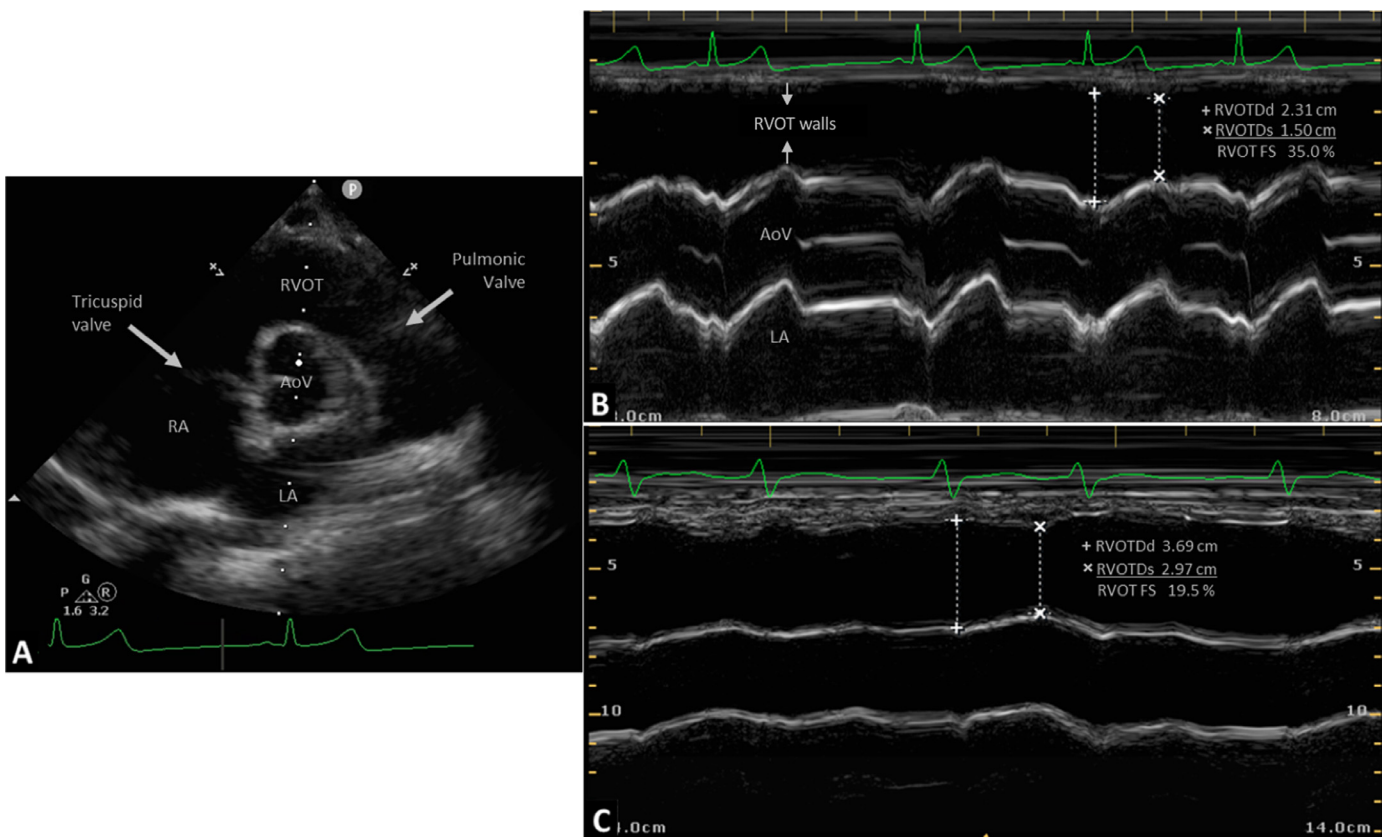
Right ventricular outflow tract fractional shortening by transthoracic echocardiography. (A) Two-dimensional image of parasternal short-axis view, aortic valve level describing the image acquisition before M-mode imaging of right ventricular outflow tract fractional shortening; the M-mode line (white dotted line) is placed through the right ventricular outflow tract, aortic valve, and left atrium; then, M-mode imaging can be recorded. The right atrium, tricuspid valve (left arrow), and pulmonary valve (right arrow) also are seen. (B) M-mode image of normal right ventricular outflow tract fractional shortening (35.0%) suggesting normal right ventricular function. The right ventricular outflow tract walls (arrows), aortic valve, and left atrium are depicted across several cardiac cycles. (C) M-mode image of abnormal right ventricular outflow tract fraction shortening (19.5%) suggesting right ventricular dysfunction. AoV, aortic valve; LA, left atrium; RA, right atrium; RVOT, right ventricular outflow tract; RVOT FS, right ventricular outflow tract fractional shortening; RVOTDd, RVOT diameter at end-diastole; RVOTDs, RVOT diameter at end-systole.
